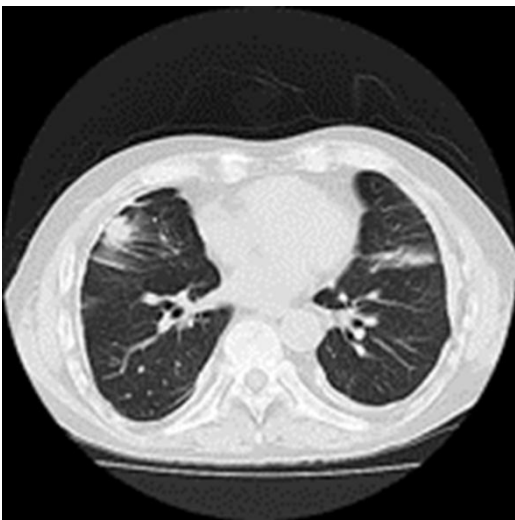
Chest CT showing lung conditions of the same case. Both pleura show diffuse hyperplasia without irregularity accompanied by visceral pleura lesions in the right lung field with round atelectasis.
